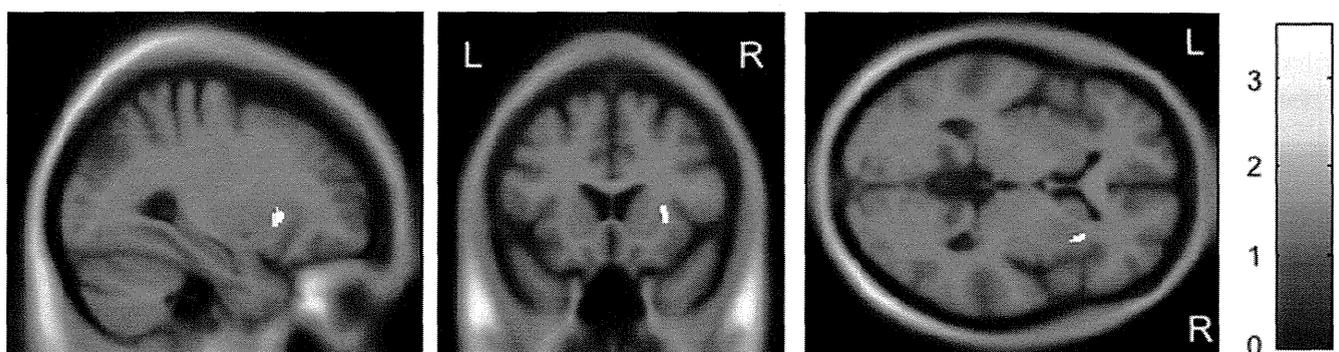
Impact of the *rs28365859* genotype on gray matter volume of left insula in schizophrenia. Age, sex, illness duration, and medication dose were used as covariates. The protective C allele carriers had a significantly larger left insula than the G homozygotes. Anatomical localizations are displayed on the normal template MR images in three directions. The color bar shows t values corresponding to the color in the figure.
